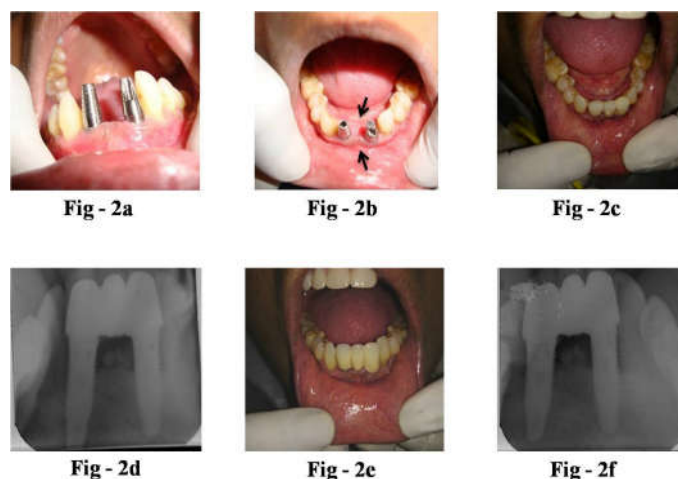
2a - Implants with prosthetic abutments. 2b - Arrows indicate the augmented site showing increase in facio - lingual width of alveolar bone. 2c - fully functional metal ceramic prosthesis. 2d - 3rd - year post operative radiograph demonstrates normal periimplant bone structures around both implants and no signs of periimplant radiolucencies. 2e and 2f - At the 5th-year examination, rehabilitation was functional, the clinical status demonstrates a healthy periimplant mucosa. 5th - year radiograph shows stable bone level for both the implants
